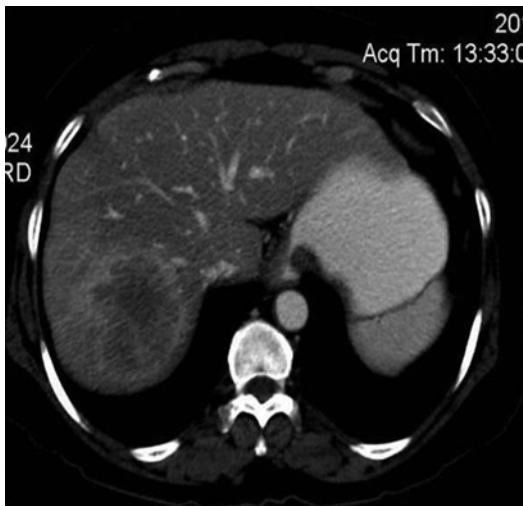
Contrast-enhanced CT showing moderate-sized solitary hepatic deposit with enhancing periphery and necrotic center in an operated case of uterine carcinoma
